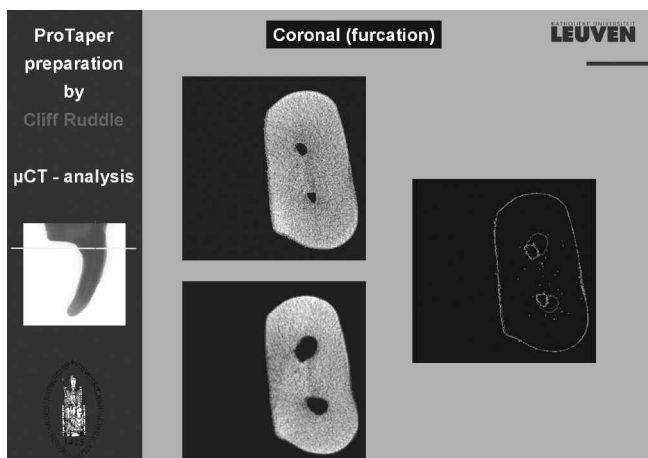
This figure shows horizontal μ CT sections through the “coronal” one-third of the root. Note the successful relocation of the canals at this level.
